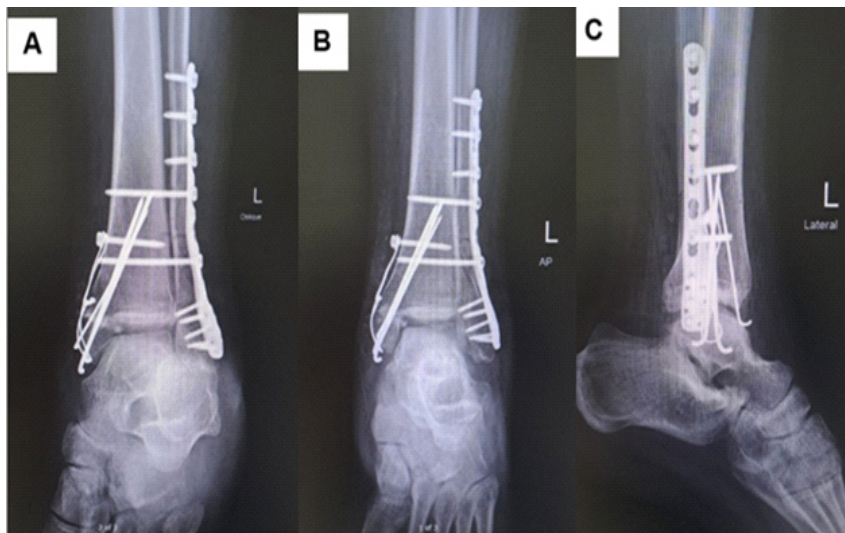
Post-operative oblique (a), anteroposterior (b), and lateral (c) X-rays showing dual syndesmosotic screw fixation and confirming restored ankle joint.
